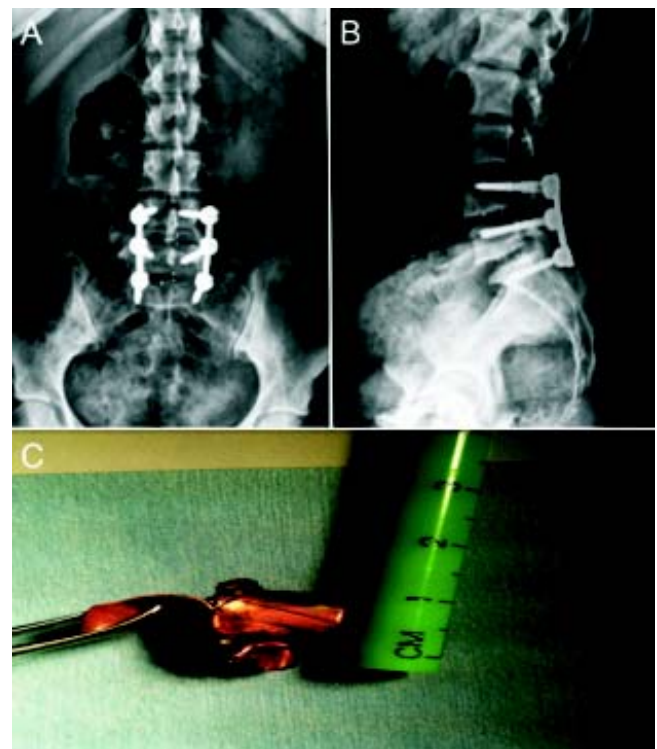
A and B. AP and lateral plain films of the lumbar spine shows fixation of the spine with metallic rods. C. Extraction of the firearm bullet (approximate diameter of 15 mm).
